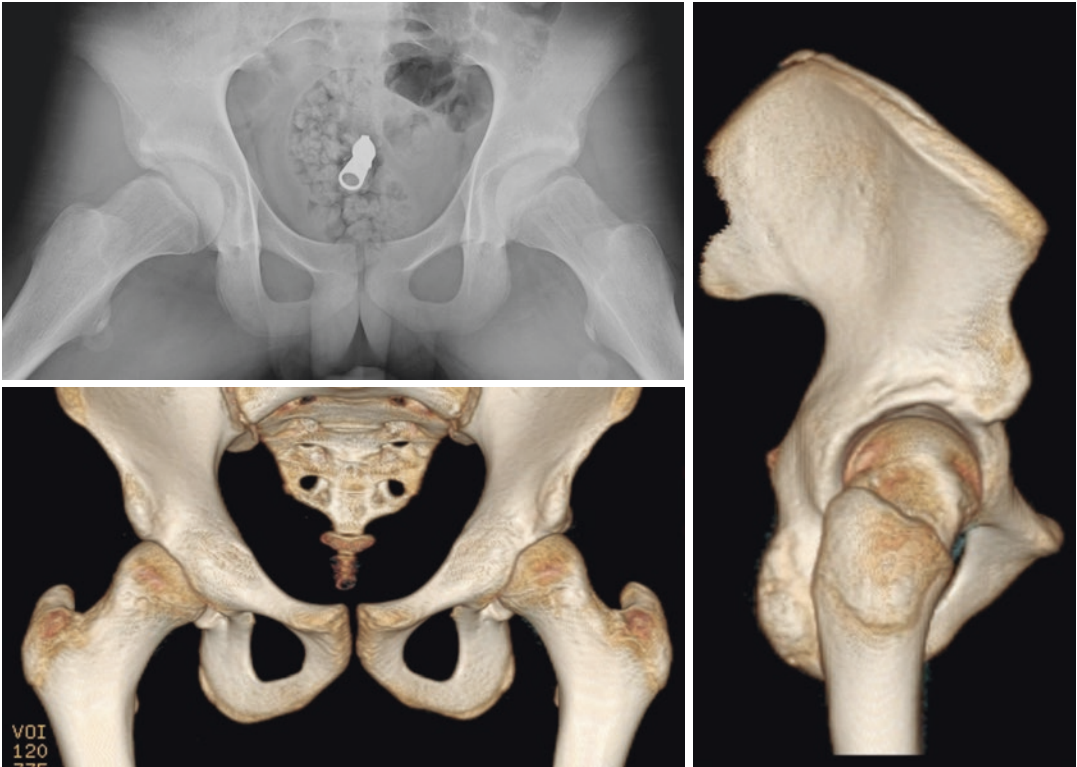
Radiographs and 3D-CT study shows the antero-lateral prominence at the head-neck junction noted in a very athletic teenage male who presented with hip pain
